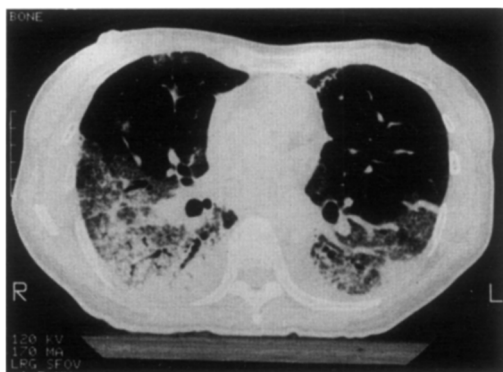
HRCT of the lower lungs shows subpleurally-located consolidation with air-bronchogram effect, and diffuse lower lobe 'ground-glass' opacification which are well demarcated from the relatively normal lung located anteriorly.
